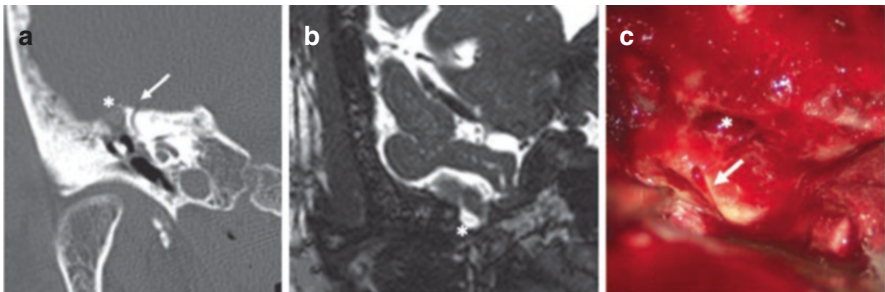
Concurrent encephalocele of the right temporal bone. (a) Coronal high-resolution CT of the temporal bone showing a concurrent encephalocele (*) and superior canal dehiscence (arrow). (b) Heavily weighted T2 coronal MRI confirming the encephalocele. (c) Intraoperative photo showing the superior canal dehiscence (arrow) and the tegmen tympani defect (arrow)
